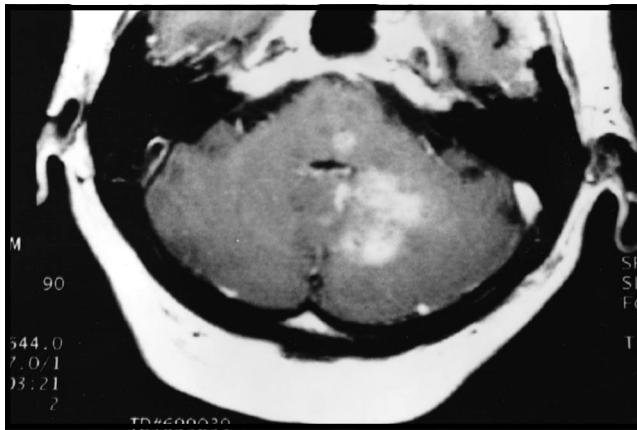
Magnetic resonance imaging with gadolinium enhancement (Axial T1 weighted) showing multiple ring enhancing lesions in the pons and the left cerebellar hemisphere.
